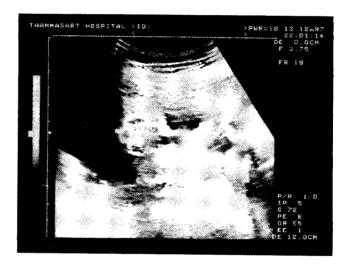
Ultrasound print showing protruded bowel from the fetal abdomen.
